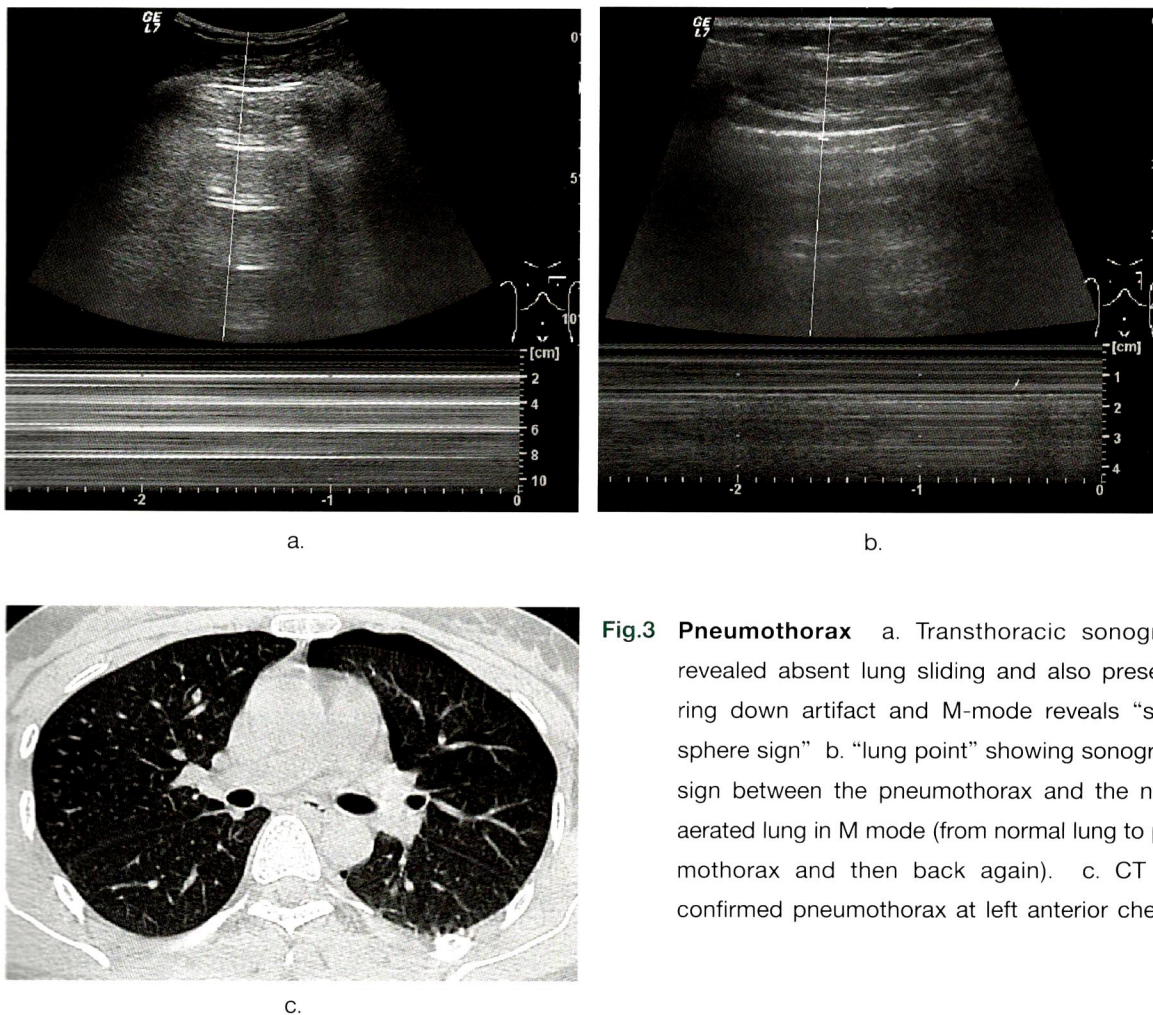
Pneumothorax a. Transthoracic sonography revealed absent lung sliding and also present of ring down artifact and M-mode reveals “stratosphere sign” b. “lung point” showing sonographic sign between the pneumothorax and the normal aerated lung in M mode (from normal lung to pneumothorax and then back again). c. CT scan confirmed pneumothorax at left anterior chest
